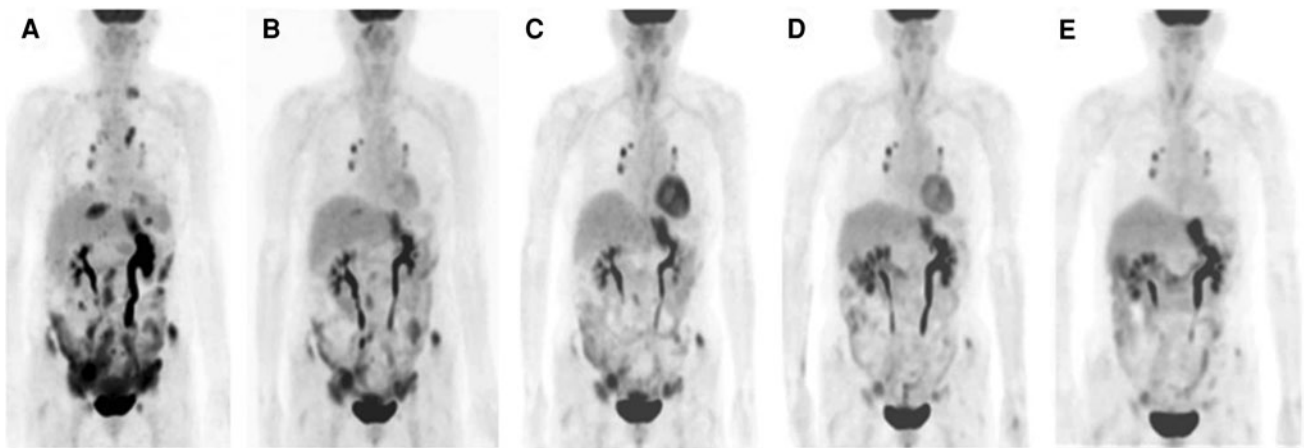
Serial images of ^{18}F -FDG PET/CT showing a decrease in tumor volume following repeated RIT with ^{131}I -rituximab (A) Baseline image from a patient with relapsed marginal zone B cell lymphoma involving multiple lymph nodes (the supraclavicular, mediastinal, intra-abdominal/pelvic, and inguinal nodes) and left-sided hydronephrosis. The images B to E were taken at 1 month after
